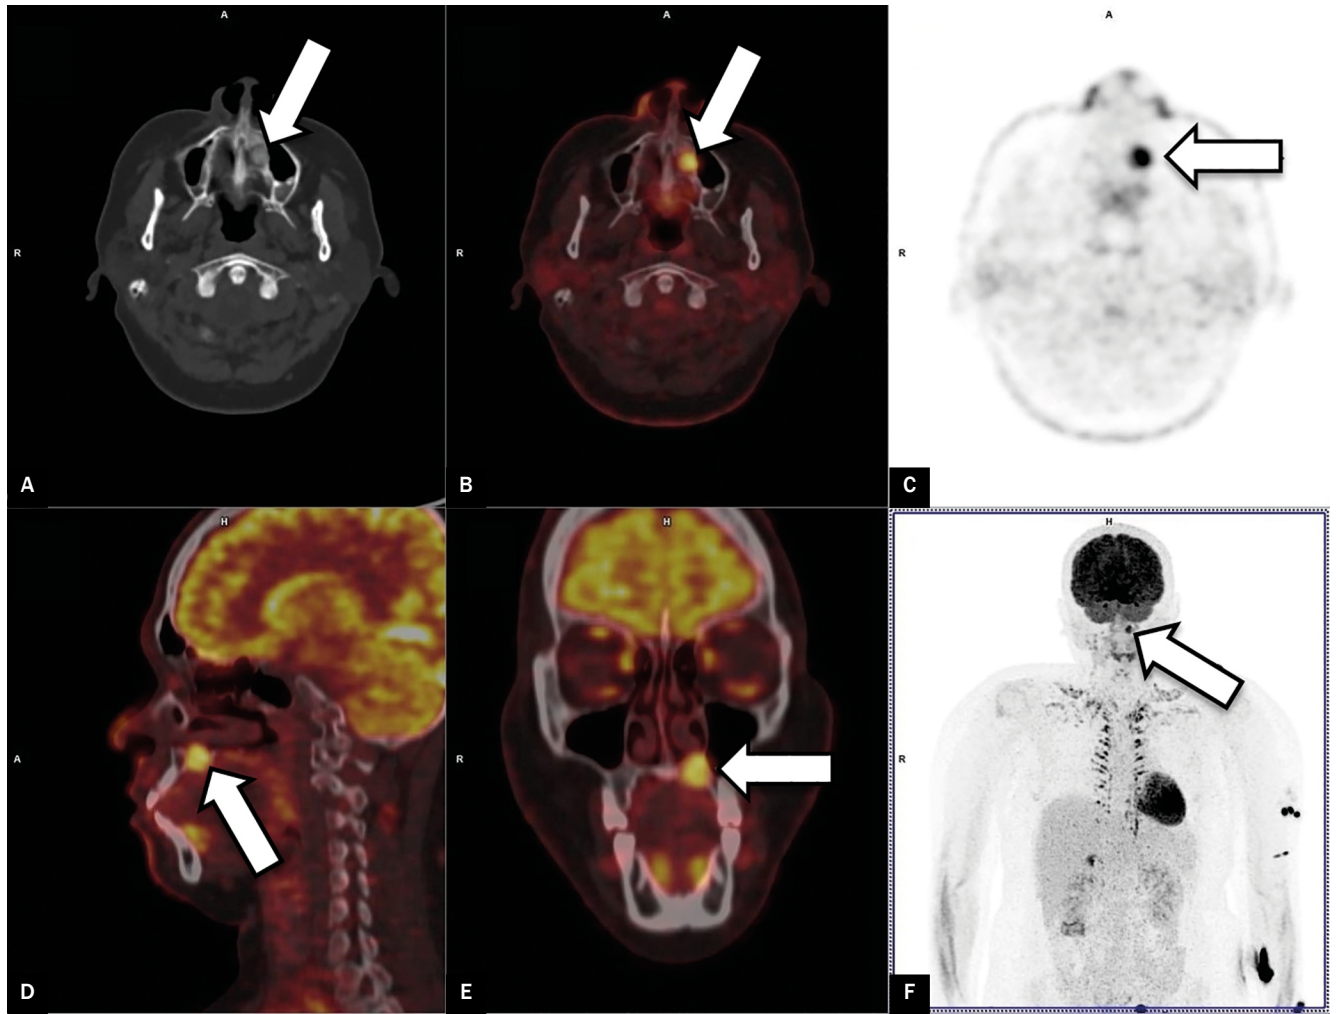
[¹⁸F]FDG PET/CT displayed in axial CT projection (A), axial fused PET/CT projection (B), axial PET maximum intensity projection (C), sagittal fused PET/CT projection (D), coronal fused PET/CT projection (E), and PET maximum intensity projection (F). The images show an expansile ossified lesion with focal [¹⁸F]FDG uptake, indicated by arrows, seen in the left palatine process of the maxilla on the [¹⁸F]FDG PET/CT. The lesion was later proven to be an ossifying fibroma
